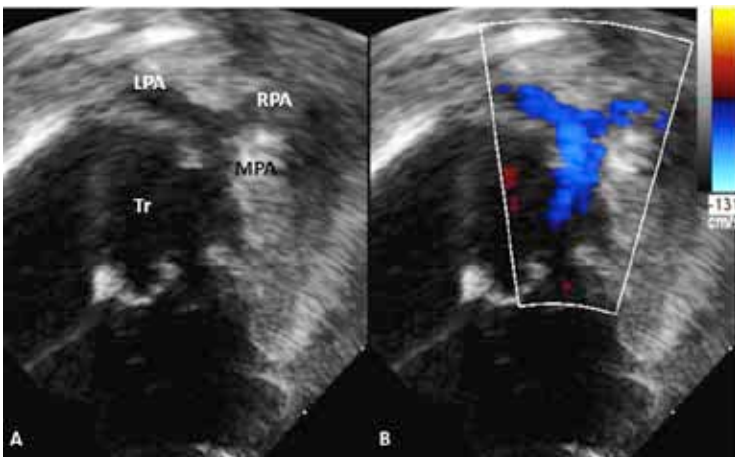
Apical 4-chamber views [2D (A) and color Doppler (B)] with anterior tilt of the transducer demonstrate main pulmonary artery (MPA) originating from the left side of the truncus (Tr) which bifurcates into right (RPA) and left (LPA) pulmonary arteries.
